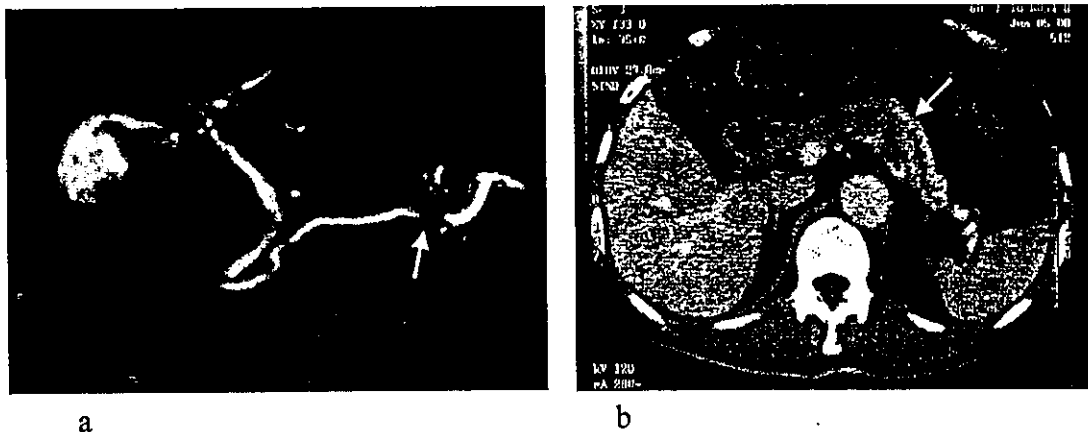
Typical images of pancreatic carcinoma produced by MRCP and dynamic CT. A: MRCP image demonstrates the stenosis of the main duct in the pancreatic body. B: CT scan shows a small cancer <2 cm in diameter in the body of the gland that corresponds with the site of the stenosis shown in the MRCP image (arrow).
